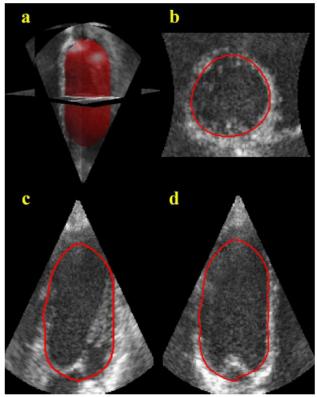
Example of LV segmentation in 3D echocardiography data obtained through a semi-automatic method. a: triplane-view and 3D rendering; b: short-axis view; c and d: long axis views. Reproduced from [67].
